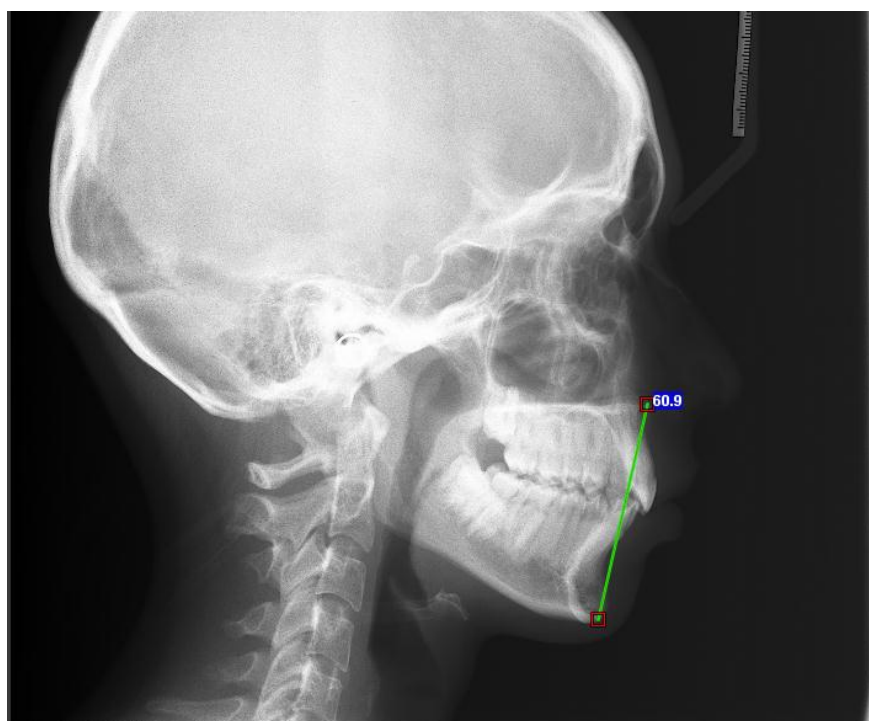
Lateral cephalometric radiograph showing the measurement between ANS to Gn
